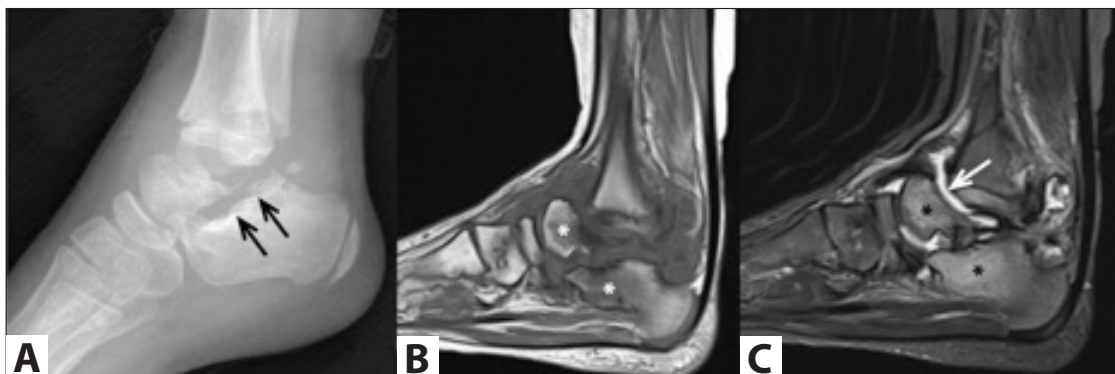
In the lateral ankle radiograph (A), bony destruction (black arrows) of talus and calcaneus and millimetric bone fragments are consistent with neuropathic arthropathy. On sagittal pre-contrast T1-weighted (B) and sagittal fat-suppressed T2-weighted (C) images, joint effusion (white arrow) accompanies bone marrow edema (asterisks) consistent with osteitis in the talus and calcaneus..
